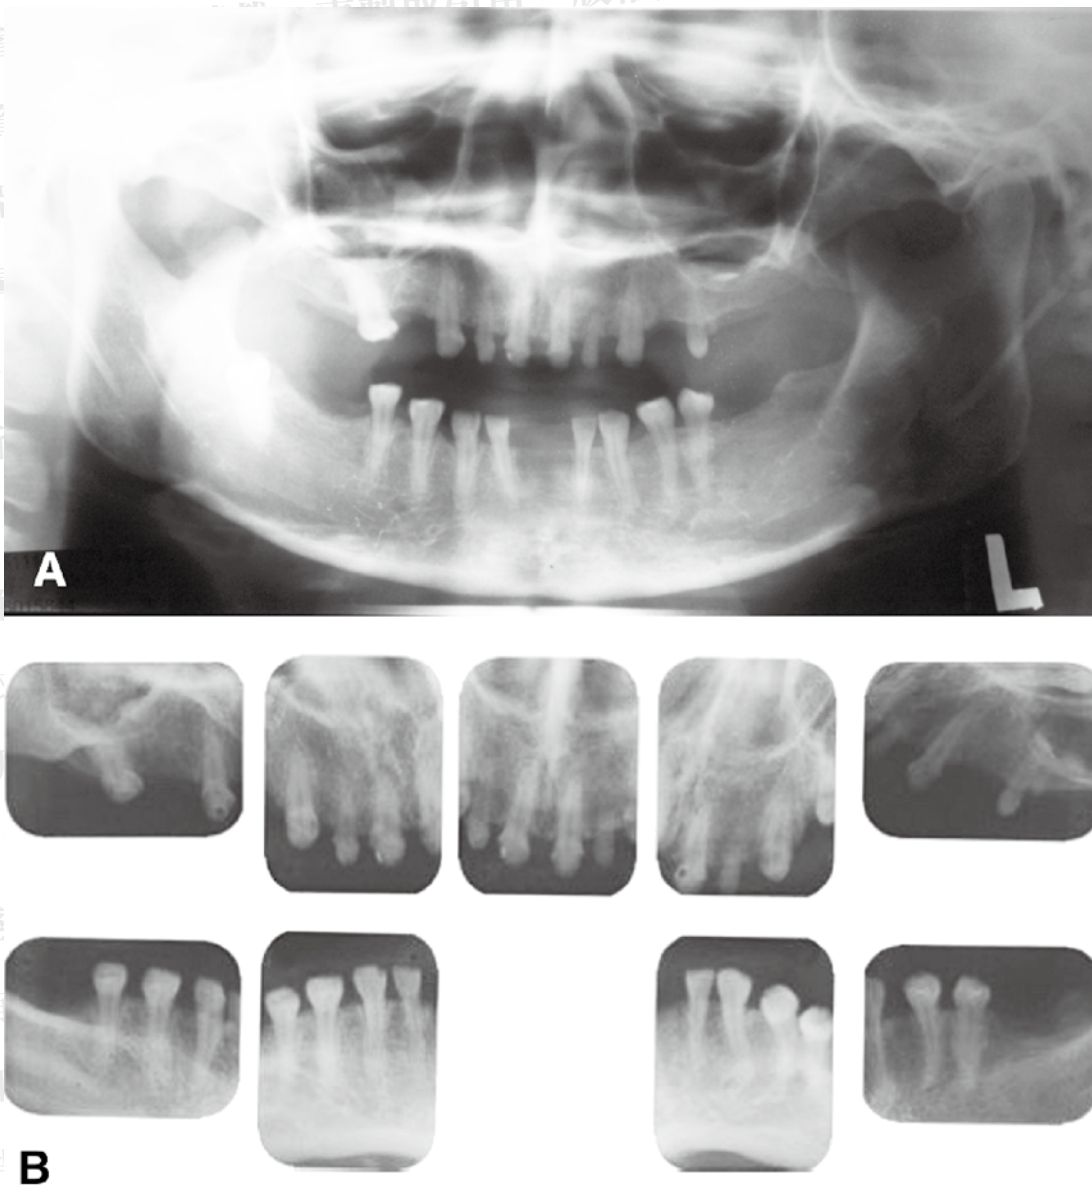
The radiographic images before treatment: (A) panoramic film, (B) peri-apical films
